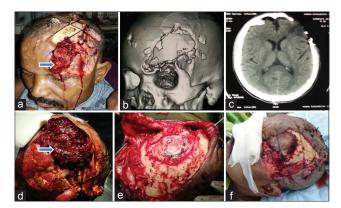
(a) Patient in emergency department showing scalp injury with fungating brain mass, (b) three-dimensional reconstructed skull view showing loss of left fronto parietal bone extending upto supra orbital ridge, (c) computed tomography scan showing bone defect with underlying edema but no mass effect or hematoma, (d) brain parenchyma protruding through skull defect, (e) repair of dural defect with pericranium, (f) patient after dural repair ready for free flap scalp defect repair
